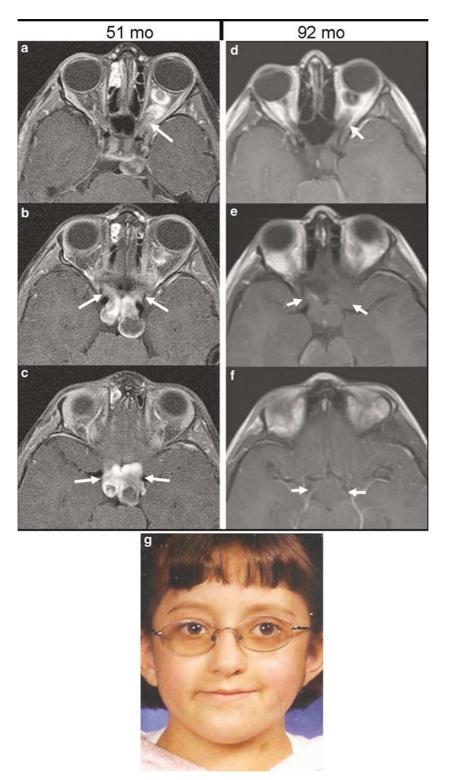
(a–f) Axial orbit MR images obtained from patient #2. (a–c) T1-weighted post-contrast fat suppression images obtained at the age of 51 months show glioma involving left intraorbital optic nerve (a, arrow), both intracranial optic nerves (b, arrows) and chiasm (c, arrows). Gliomatous cysts extend from the posterior aspect of the chiasm filling the suprasellar cistern. (d–f) T1-weighted post-contrast images obtained at the age of 92 months. The patient had been treated with chemotherapy. There is marked reduction in the enhancement and cystic components of the glioma. The entire left optic nerve, right intracranial optic nerve and chiasm (short arrows) remain enlarged. (g) External photograph of patient #2 at 7 years of age. Mild proptosis and exotropia of the left eye is evident. A café-au-lait spot is seen on the left side of her neck.
